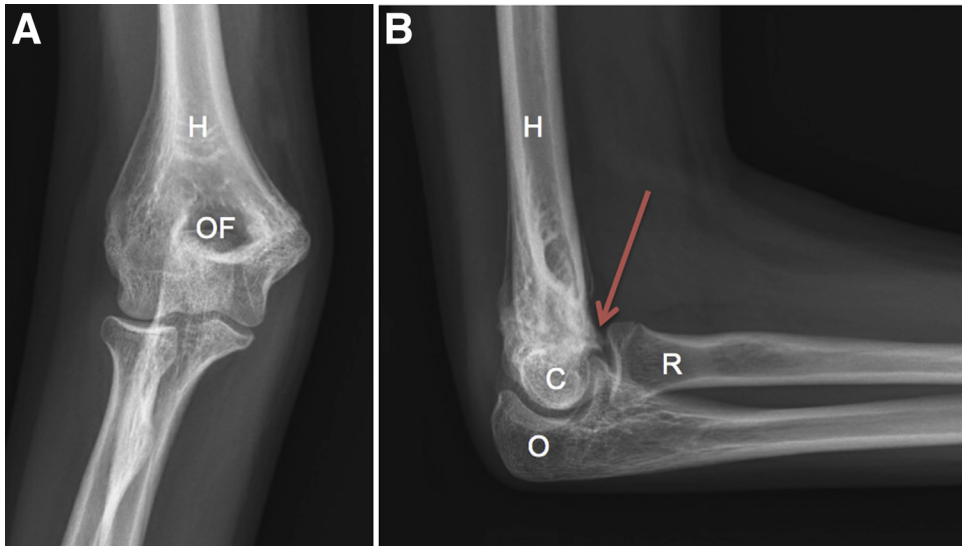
Anteroposterior (A) and lateral (B) radiographs of a right elbow showing extension malunion of the distal humerus with heterotopic bone anteriorly as depicted by the red arrow. (C, capitellum; H, humerus; O, olecranon; OF, olecranon fossa; R, radius.)
